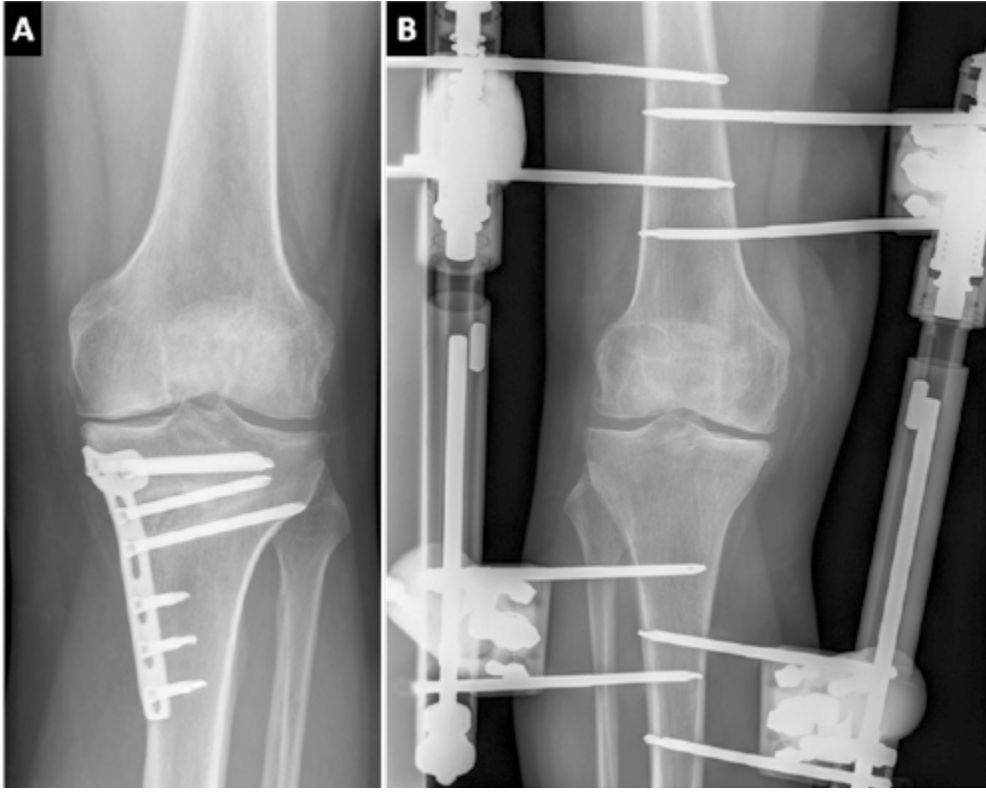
Examples of postoperative radiographs, A left knee treated with high tibial osteotomy, B right knee treated with knee joint distraction.
